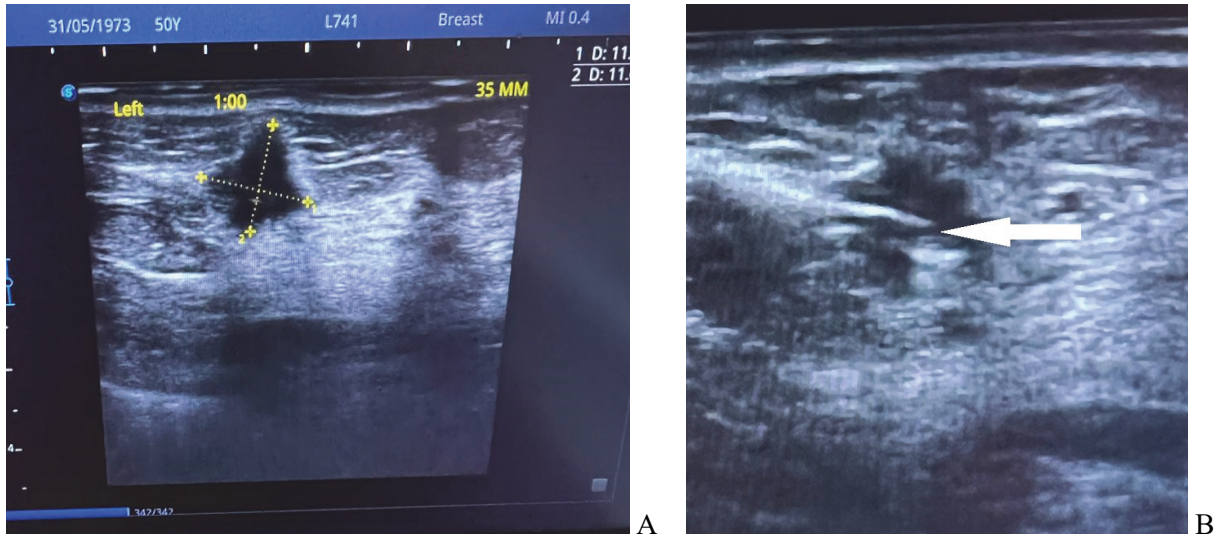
Preoperative ultrasonography (US)-guided surgical clip insertion. A – Visualization of tumor by US. B – The clip insertion (on US images, the coaxial needle (arrows) is visible as an echogenic white line and the clips show a linear hyperechogenic structure in the center of the proven tumor.
